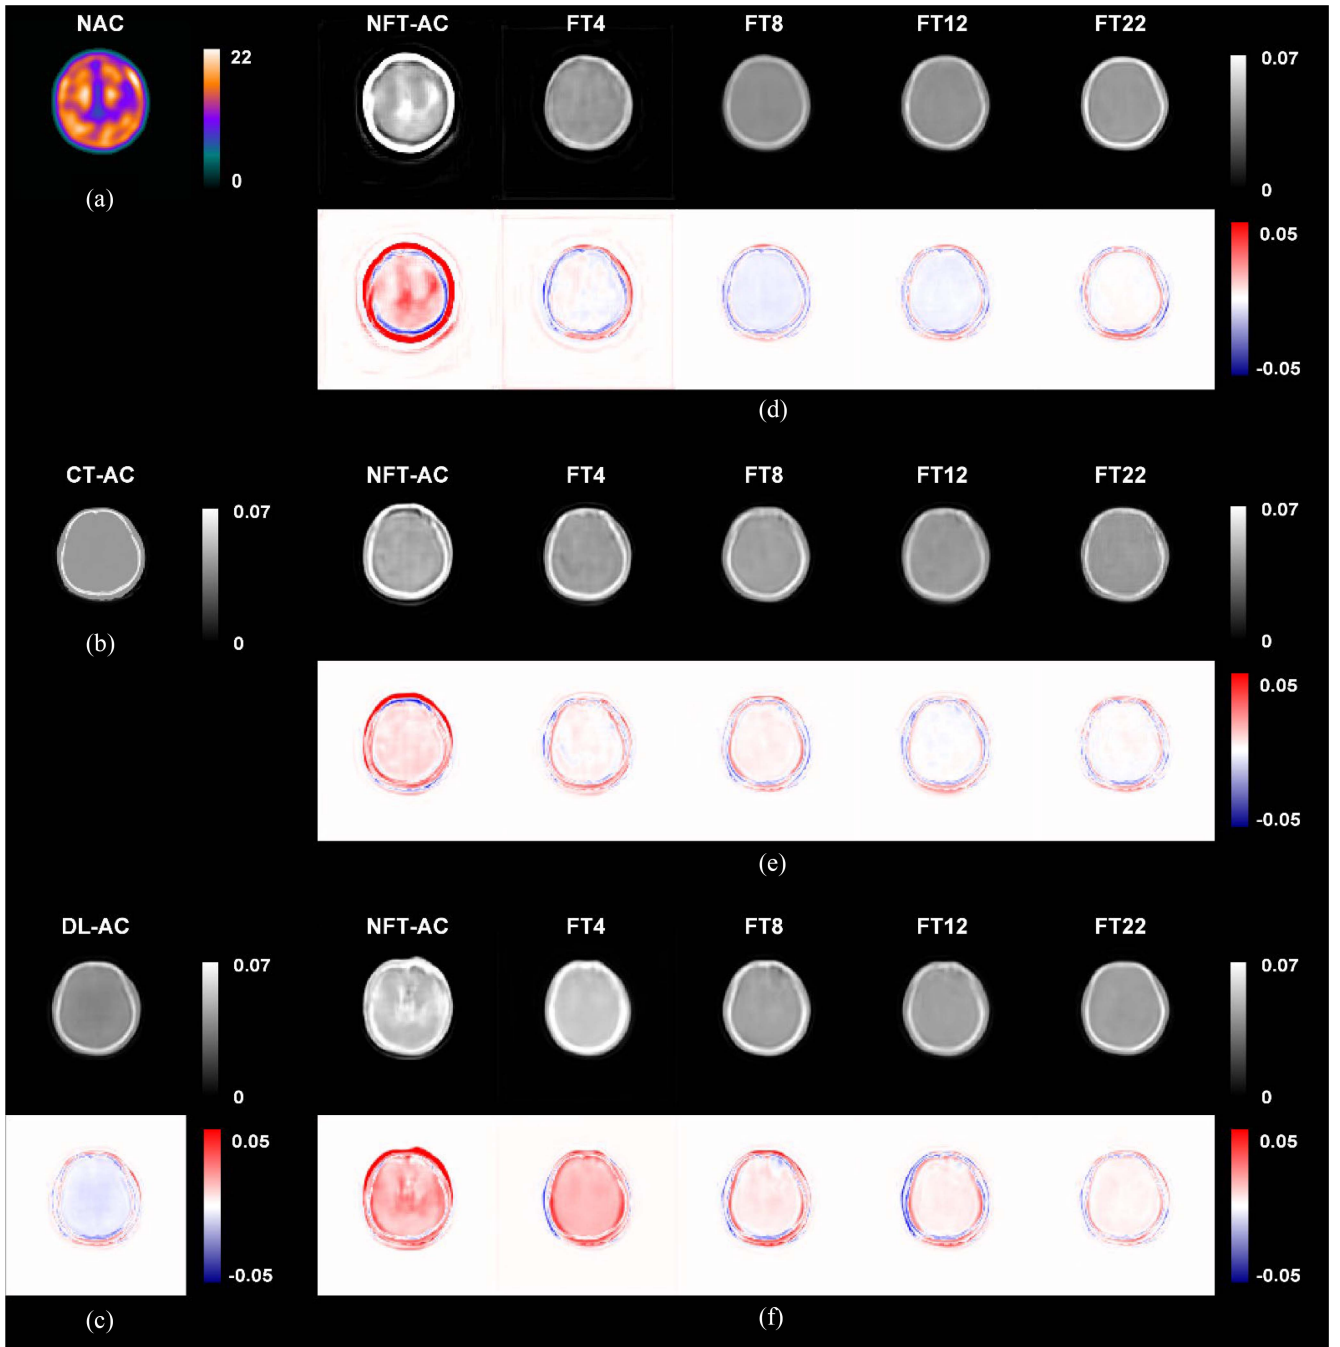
Representative results of an 81-year-old male patient. Sample axial (a) NAC SPECT image and  $\mu$ -maps images of (b) CT-AC, (c) DL-AC, NFT-AC, and FT-AC methods with different numbers of FT data for the tested S-TRODAT-1 data using (d) S-ECD (cross-tracer), (e) G-TRODAT-1 (cross-scanner), and (f) G-ECD (cross-tracer+cross-scanner) as the pretrained network. The corresponding error map as compared to CT-AC is shown under each DL-generated  $\mu$ -map image, respectively.
